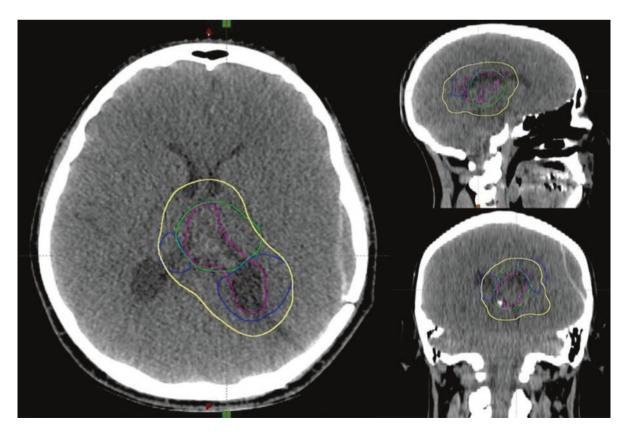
Planning CT treatment volumes: pre-op tumor (green), pre-op cyst (blue), CTV (pink), and PTV (yellow)
